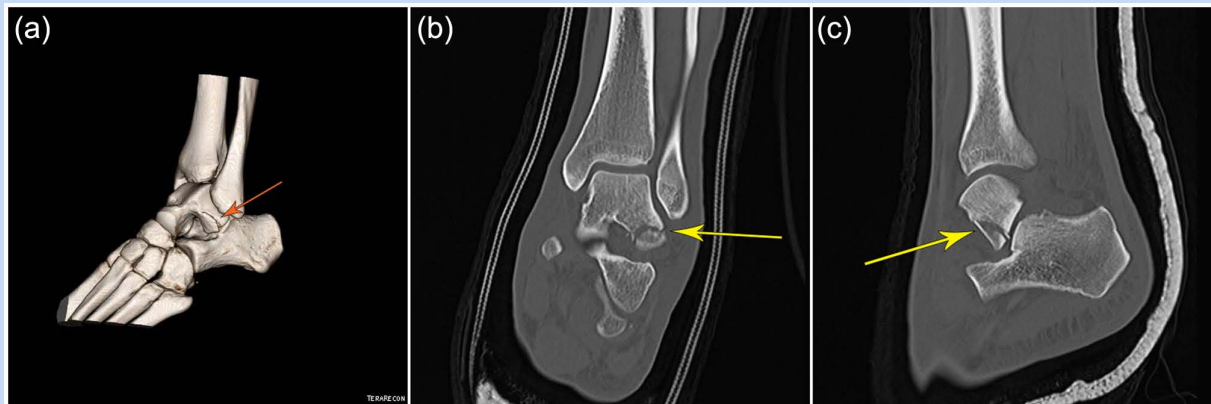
(a) Three-dimensional CT reconstruction depicting fracture through the lateral process of the talus. (b) Coronal and (c) sagittal images from a CT scan showing a fracture through the lateral process of the talus.
